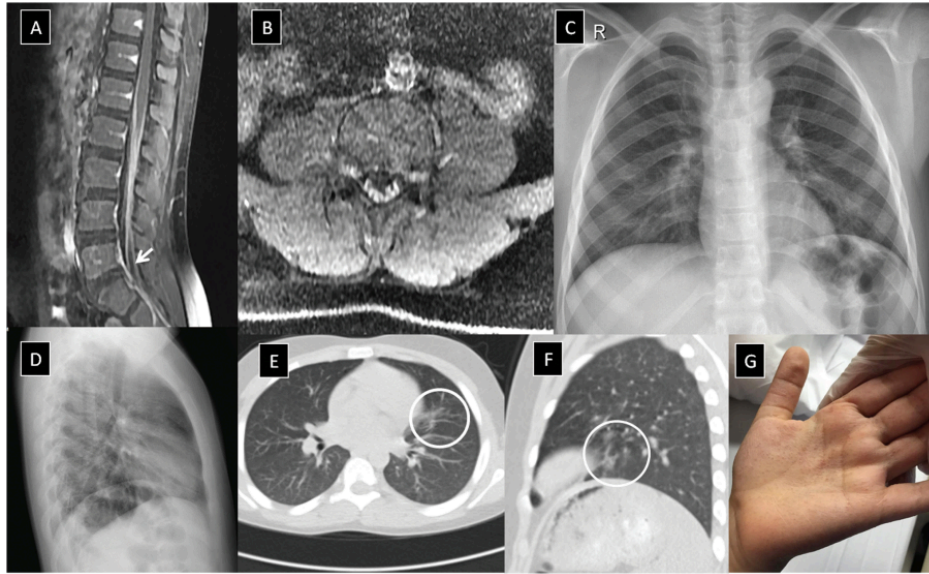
A and B, Sagittal and axial T1 fat saturation postcontrast magnetic resonance imaging showing cauda equina nerve root enhancement (white arrow) indicative of Guillain-Barré syndrome. C and D, Chest radiograph postanterior and left lateral views showing bilateral paracardiac and basal veiling. E and F, Computed tomography of the chest showing small patchy subsegmental faint opacity with atelectasis band in the lingula on the week after admission (white circles). G, Morbilliform skin rash over the palmar aspect of the left hand.
